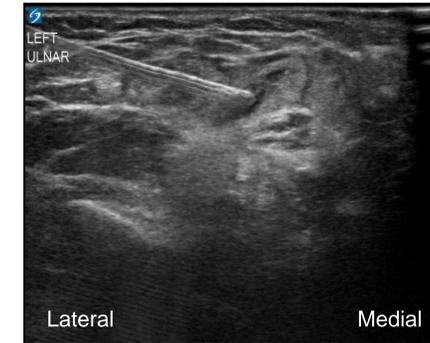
Ultrasound guided hydrodissection of the left transpositioned ulnar nerve.
